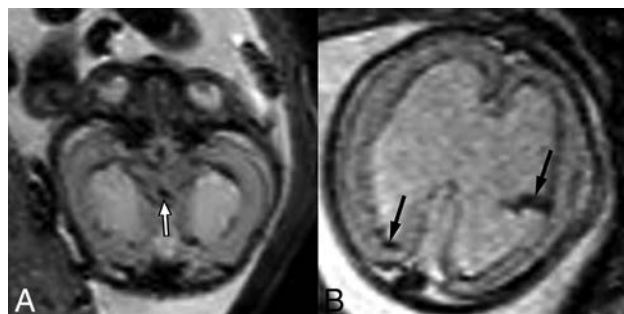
T2-weighted EPI sequences of 2 different fetuses with aqueductal stenosis demonstrating T2-hypointense hemorrhage within the cerebral aqueduct (A) in a 21-week fetus (white arrow) and within the lateral ventricles (B) in a 23-week fetus (black arrows).
